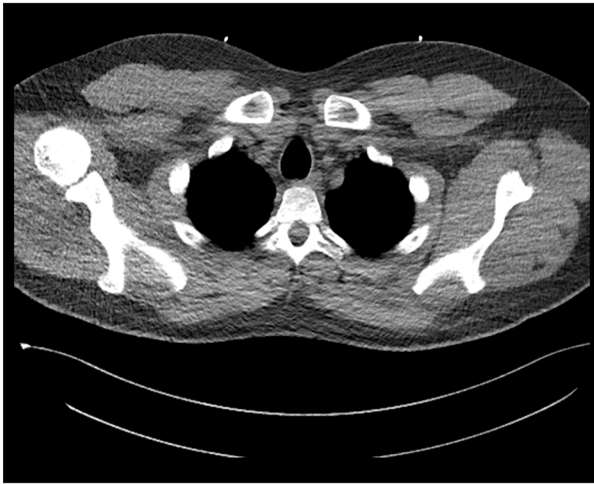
Thoracic CT at day 6: Pneumomediastinum and soft-tissue emphysema completely regressed.
